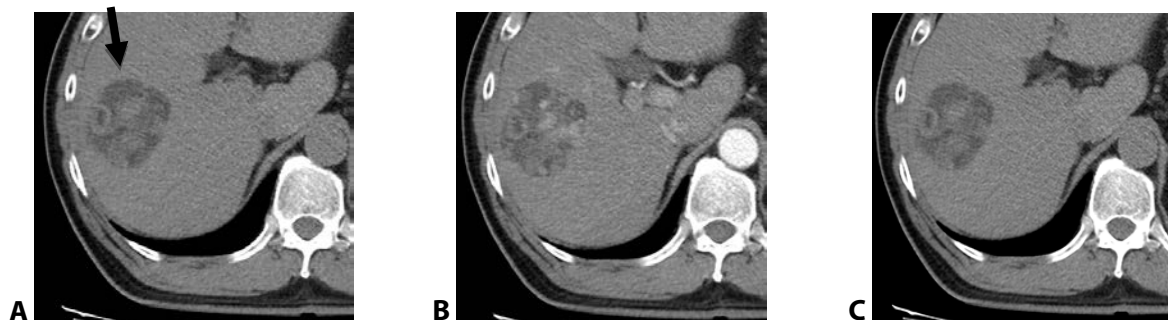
CT scan finding of case 2. A. Non-enhanced CT. A tumor (arrow) of 52x56x52mm was discovered in subsegments V, VIII, and a small portion VI. The tumor has clear boundaries, multi-arc margins, decreased density before injection, and some areas have fat density. B, C. Arterial phase and portal phase: It showed heterogeneous enhancement after contrast administration.
